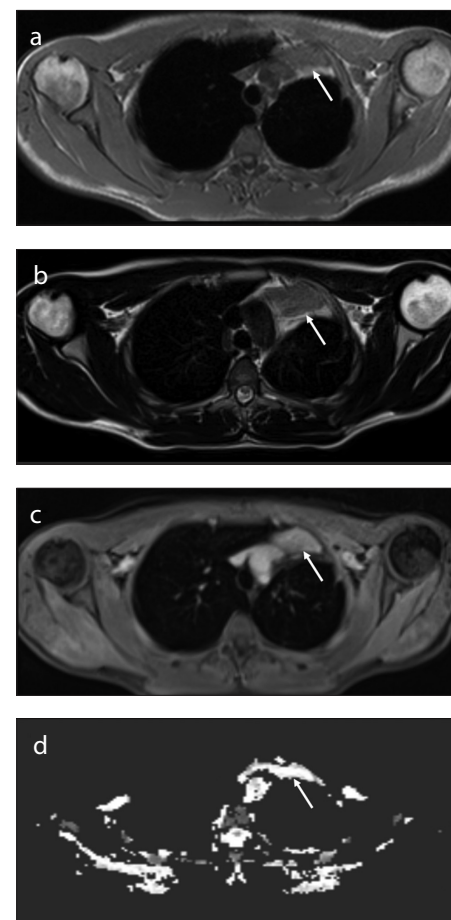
a-d. A 12-year-old male with a pathologically confirmed carcinoid tumor in the left upper lobe. Axial T1-weighted image (a) reveals the iso-hypointense carcinoid tumor (white arrow). Axial T2-weighted image (b) reveals a hypointense carcinoid tumor (white arrow). Axial postcontrast enhancement T1-weighted image (c) reveals contrast enhancement in carcinoid tumor (white arrow). Axial diffusion-weighted (ADC map) image (d) reveals no diffusion restriction (white arrow).
